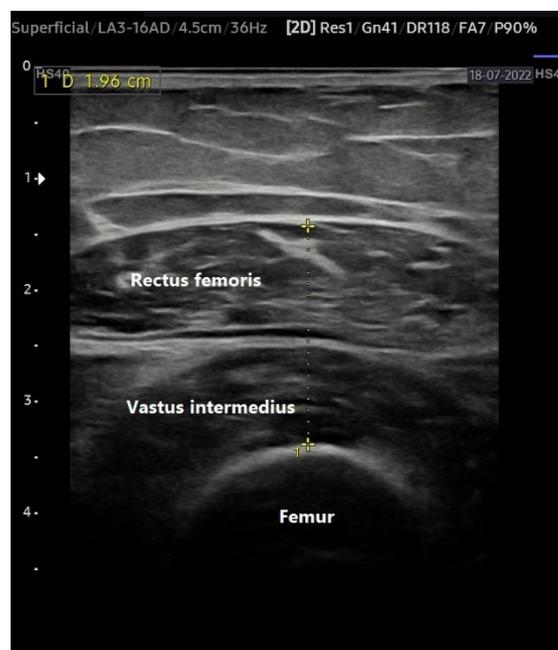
Example ultrasound assessment of the quadriceps femoris muscle thickness made by linear probe.
